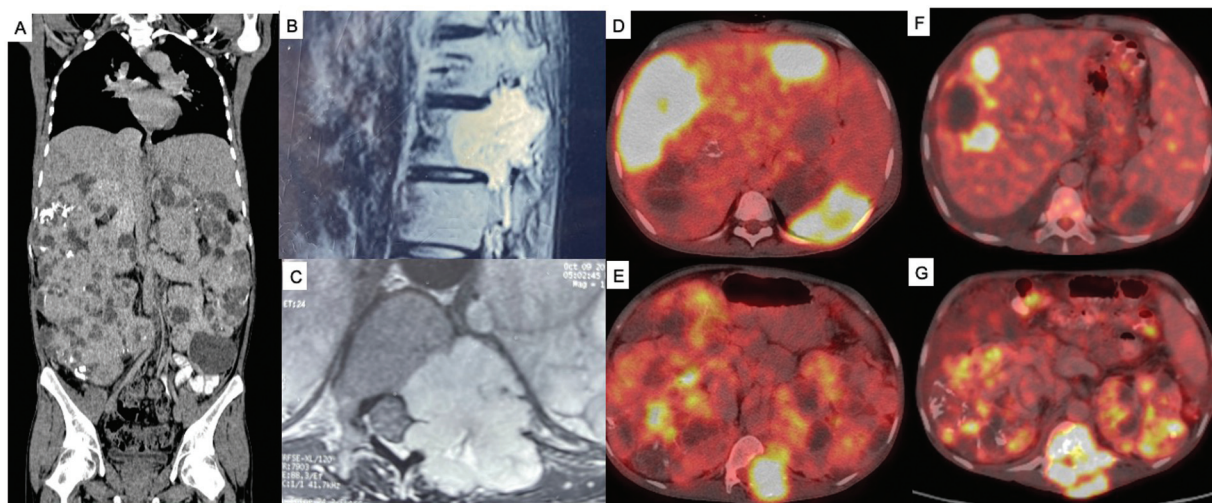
(A) Sagittal section of contrast-enhanced computed tomography (CECT) abdomen showing bilateral polycystic kidneys (Right 26.5×14 cm, Left 25.5×13 cm) with peripheral and chunky calcification, and multiple liver cysts. (B) Sagittal and (C) axial sections of magnetic resonance images of dorsolumbar spine showing a large T2 hyperintense lobulated soft tissue metastatic lesion involving D12 vertebra on left side of body, pedicle, and transverse process with involvement of adjacent costovertebral joint, epidural space extension, cord compression, and left neural foramina narrowing at D11-12 and D12-L1 levels. (D) Axial sections of corresponding positron emission tomography (PET)-CECT images showing multiple cystic liver metastases with fluorodeoxyglucose (FDG) uptake, largest in right lobe (largest 11.2×7.3 cm) with peripheral enhancement on arterial phase, and (E) multiple bilateral renal cystic masses with soft tissue component and FDG avidity, and left D12 vertebral metastases. (F) Axial PET-CECT image on follow-up showing progressive necrotic liver metastases; many new liver lesions had developed (not shown in image), and (G) progression in extent of D12 vertebral lesion and soft tissue component with cord compression.
